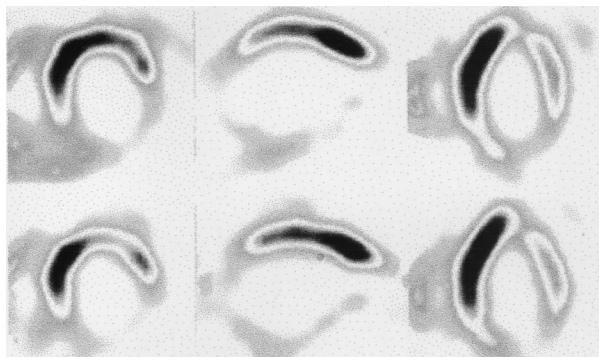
Baseline resting (lower row) and LDD (upper row) SPECT slices (from left to right: midventricular short axis, vertical long axis, and horizontal long axis) of a patient with 3-vessel coronary artery disease. A baseline severe inferior defect was not modified in the LDD images; no improvement in regional wall motion was registered after coronary artery bypass grafting.
